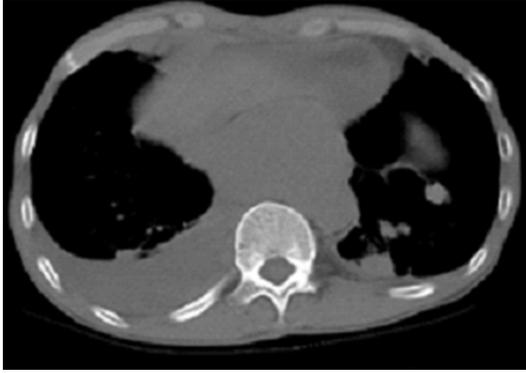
MRI showing a large soft-tissue mass in front of T8-L1.
